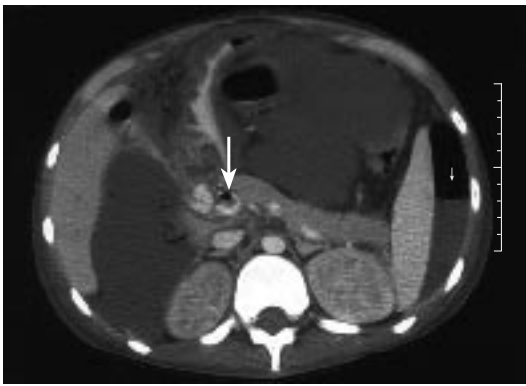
Computed tomography of the abdomen showing evidence of portal venous gas (long arrow), portal vein thrombosis, gross ascites, and pneumoperitoneum (short arrow).
